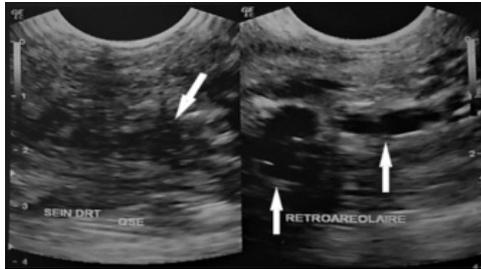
Breast ultrasound revealing a heterogeneous hypoechoic irregular and poorly marginated mass in the outer quadrants of the right breast with surrounding edema and dilatation of the milk ducts classified as BI-RADS 4.
